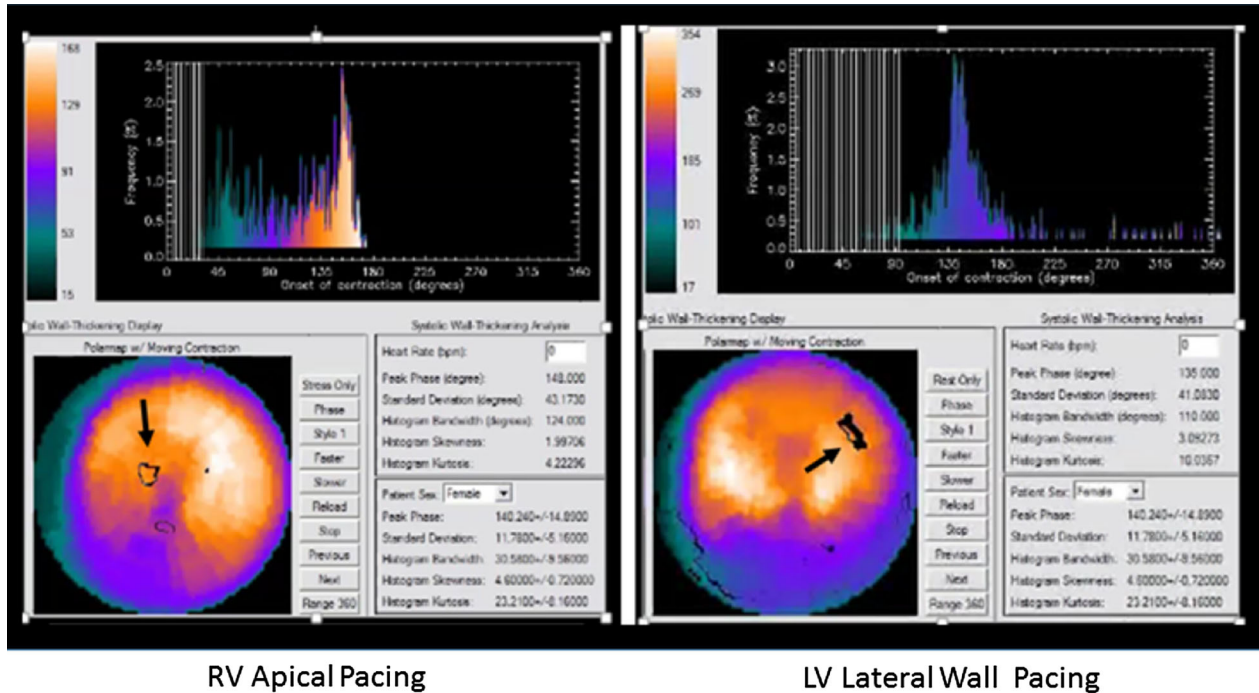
The sequence of LV regional mechanical activation evaluated by phase analysis of myocardial SPECT in a patient with a biventricular pacemaker. The *top panels* show the phase histogram and the *bottom panels* show a perfusion polar map with the region of earliest activation of the LV (*arrow*) superimposed on it. The initial scan (*left panel*) was obtained during RV apical pacing (LV lead turned off), and shows earliest activation of the LV at the apex. A subsequent scan (*right panel*) was performed with LV pacing (RV lead turned off) and shows initial activation in the antero-lateral wall of the LV, corresponding to the position of the LV lead in the coronary sinus. The phase histograms show greater dyssynchrony (wider phase histogram bandwidth) during RV pacing than LV pacing.
